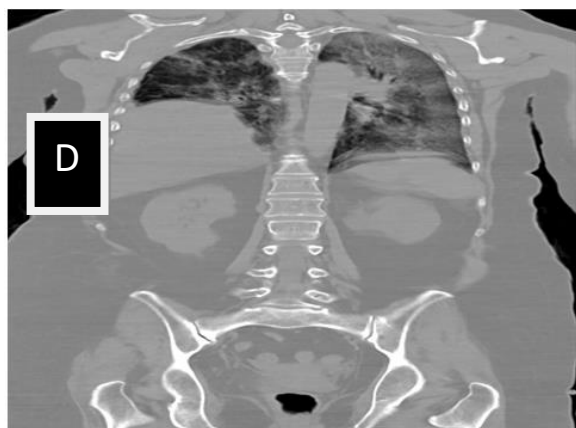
(C). Computed tomography of thorax billateral opacities
